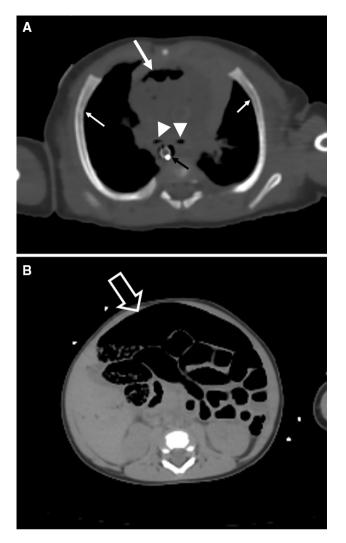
CT was performed at an unknown interval postmortem in this 8-month-old male who was status post attempted cardiopulmonary resuscitation (CPR). a An axial image with the bone window setting shows intracardiac gas (*large arrow*) which has been described in deceased patients after CPR. Inadvertent esophageal intubation is identified (*black arrow*) (*arrowheads*—right and left mainstem bronchi). There are subtle, buckle fractures of the anterolateral aspects of the 5th ribs, bilaterally, along their inner cortices (*small arrows*). Fractures in this location are known to be associated with CPR, whereas posterior rib fractures are not. b There is pronounced gaseous dilatation of bowel (*open arrow*) on an image through the mid-abdomen presumably due to esophageal intubation
